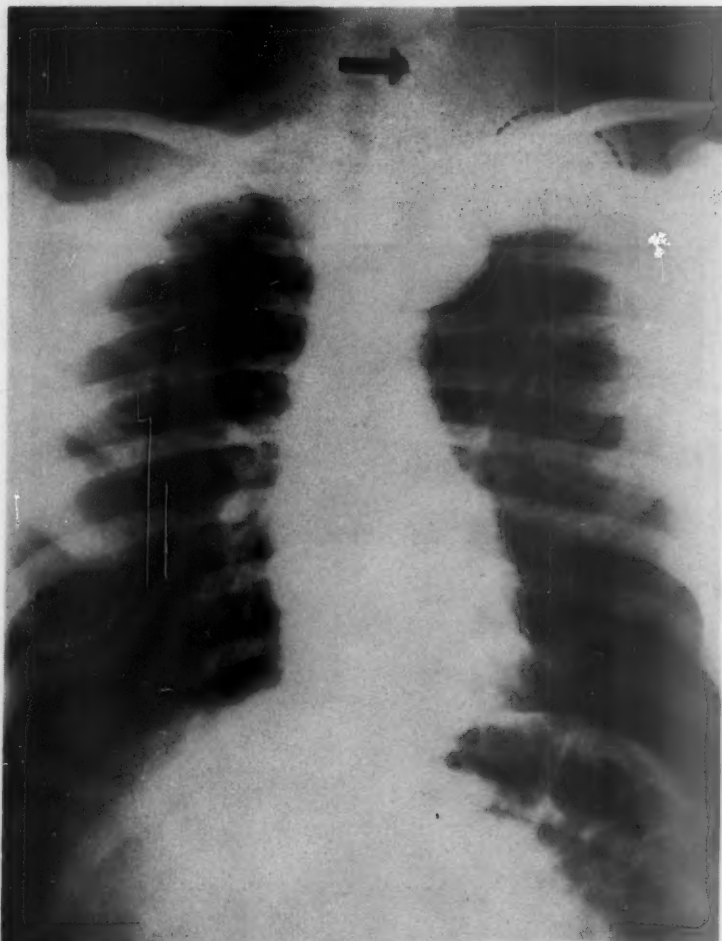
The posterior-anterior chest roentgenogram of a 19 year old white male who had a progressive paraplegia, with greater involvement of the left side. There is a large, smooth density in the left superior mediastinum. In addition to the mediastinal mass, soft tissue densities are to be noted in the left apical inlet and cervical region. These areas are outlined by dotted lines in the figure. Because of the seriousness of the condition of the patient, an immediate thoracotomy and cervical laminectomy were done, and multiple neurofibromata were removed. The patient was relieved of his paralysis, and after a prolonged convalescence returned to normal activity.
